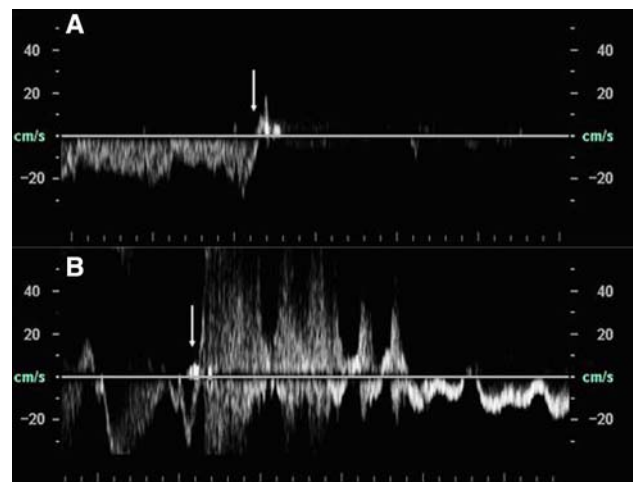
Examples of valvular functional testing with Doppler ultrasound. The beginning of the Valsalva maneuver is indicated by arrows. a Brief episode of physiological reflux during closure of a competent valve, followed by cessation of flow. b Prolonged retrograde flow jet in a patient with diagnosis of idiopathic intracranial hypertension, indicating valvular insufficiency
